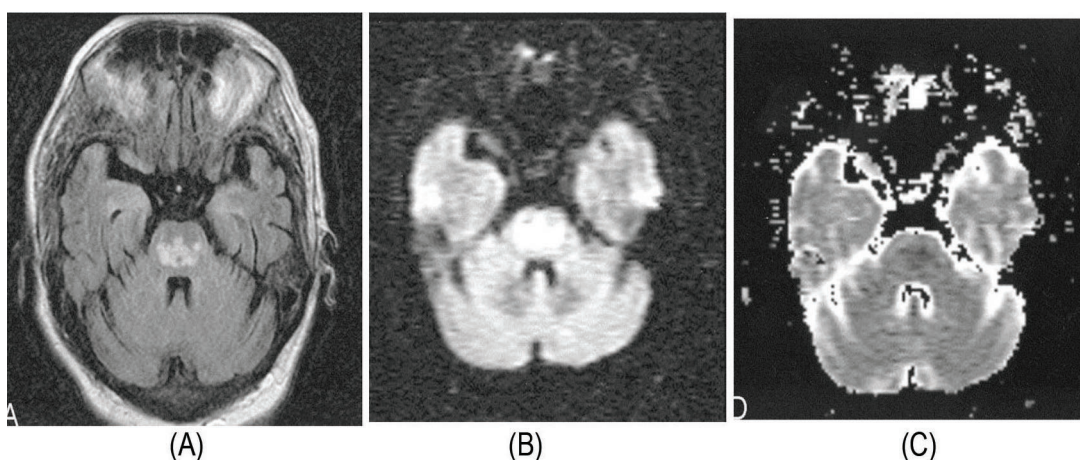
Axial FLAIR image of osmotic myelinosis showing pontine hyperintensity (A), hyperintense on DWI image (B) and hypointense on ADC (C)
